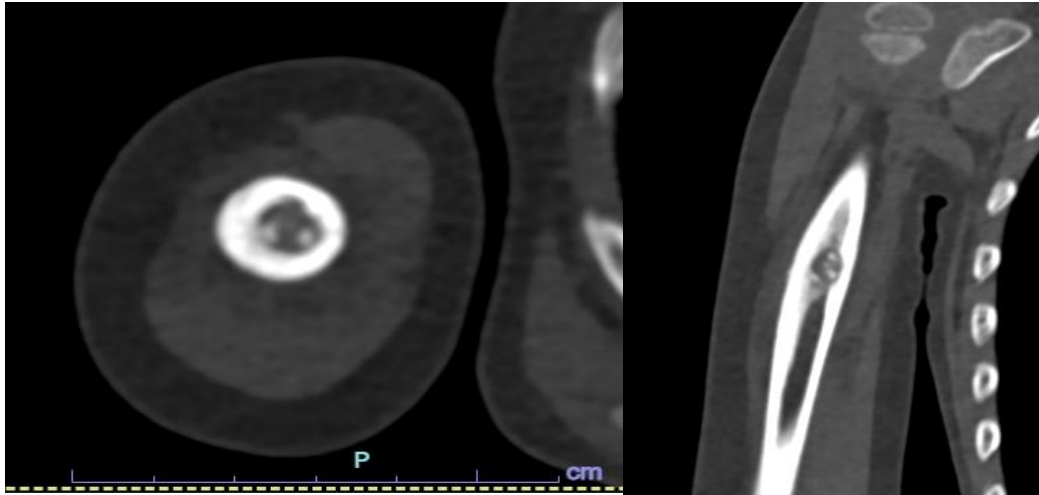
CT Axial and coronal sections showing lesion at mid diaphysis of humerus with thickened periosteum.
